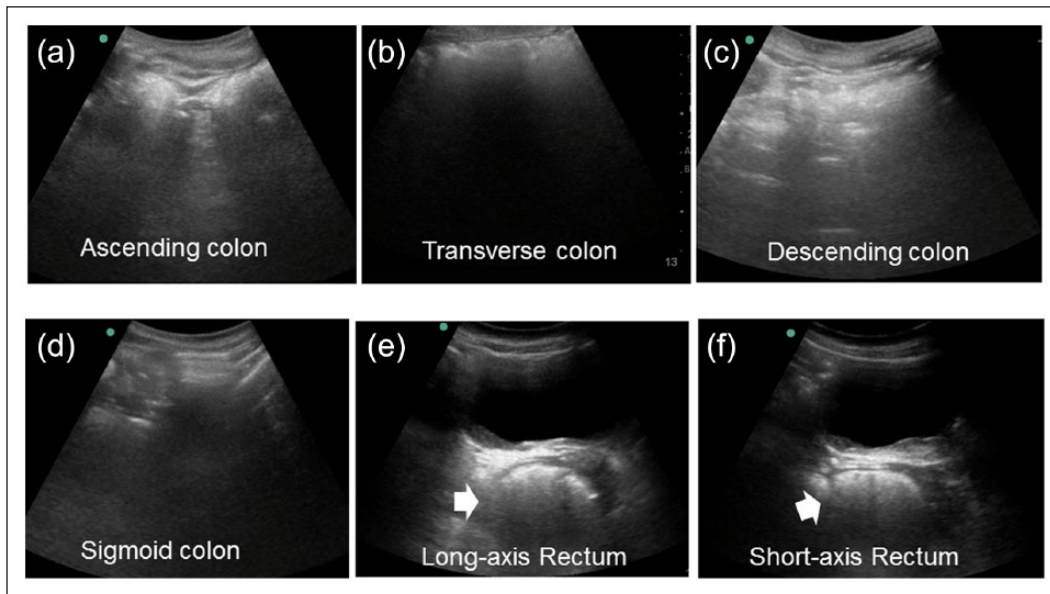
Fecal retention in the rectum case. An 82-year-old woman with chronic constipation evaluated by ultrasonography (US). (a–d) Long-axis US images show moderate amounts of gas or small feces in the colon, without fecal retention. (e and f) Fecal retention in the rectum is clearly seen as a crescent-shaped acoustic shadow (arrows).
